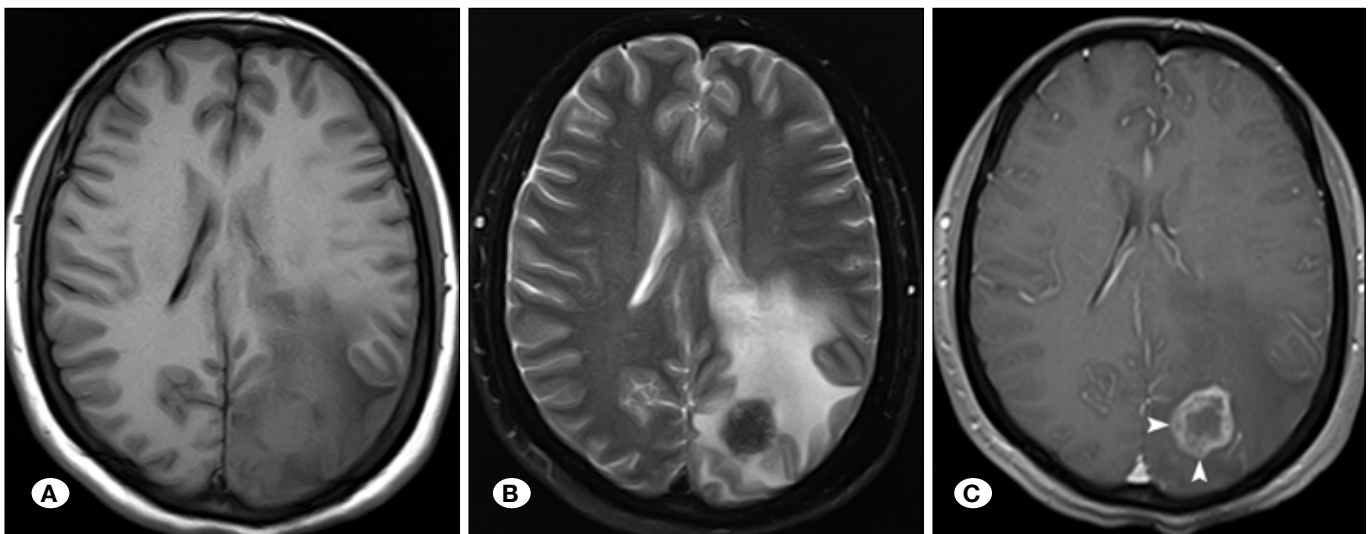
The MR imaging of a 39-year-old male with NCC. A) T1WI, B) T2WI, C) contrast-enhanced T1WI. A lesion with low signal intensity on T1 and T2WI was seen in the left occipital lobe with severe perifocal edema. The ring-like enhancement comprised by numerous annular nodules was demonstrated on contrast-enhanced T1WI (C. Arrowhead).
